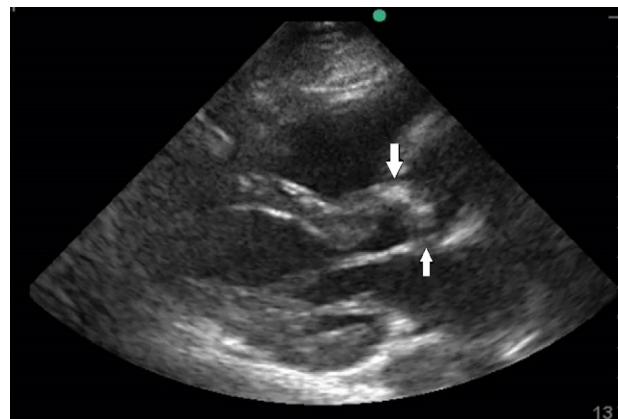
Parasternal long-axis window. Arrows show calcified and stenotic aortic valve.
